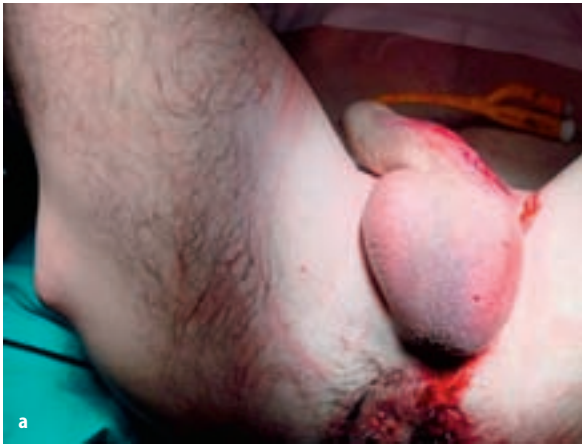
Gunshot wound to the penis. The bullet went through the corpora cavernosa, superficially damaged the urethral spongy tissue, and ended in the subcutaneous tissue of the right thigh. Urethroplasty was not required. a and b Show external aspect at admission. c CT scan showing bullet in the posterior aspect of the right thigh. (Courtesy of Dr. J.J. López-Tello)
